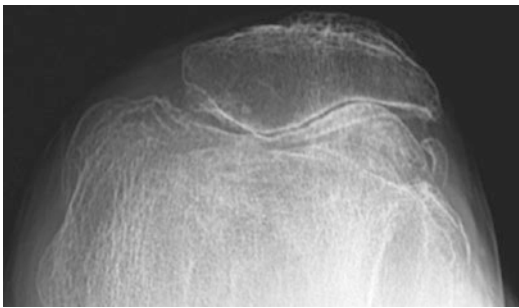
Knee Merchant radiograph shows joint space narrowing, marginal osteophytes, and subchondral sclerosis in the lateral patellofemoral compartment
